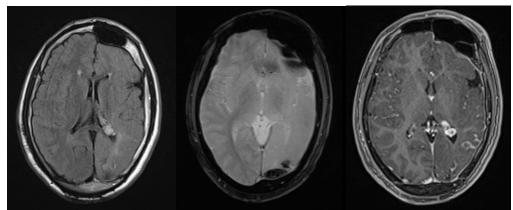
T2 FLAIR axial sequence: left parieto-occipital atrophy associated with a FLAIR hypersignal of a few left parietooccipital cortical furrows axial sequence T2*: cortical-subcortical linear signal voids in relation to calcium deposits; spin echo T1 sequence after Gadolinium injection: thickened aspect of the left choroid plexus, and lepto-meningeal enhancement related to a pial angioma
